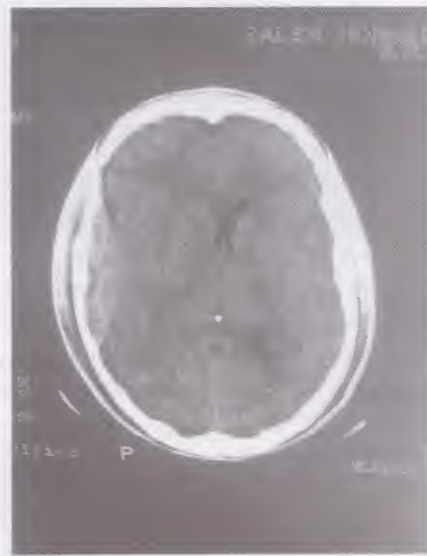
CT brain showing a peripheral high-density biconvex blood collection bounded by sutures, denoting epidural hematoma. Scalp hematoma is also present.
